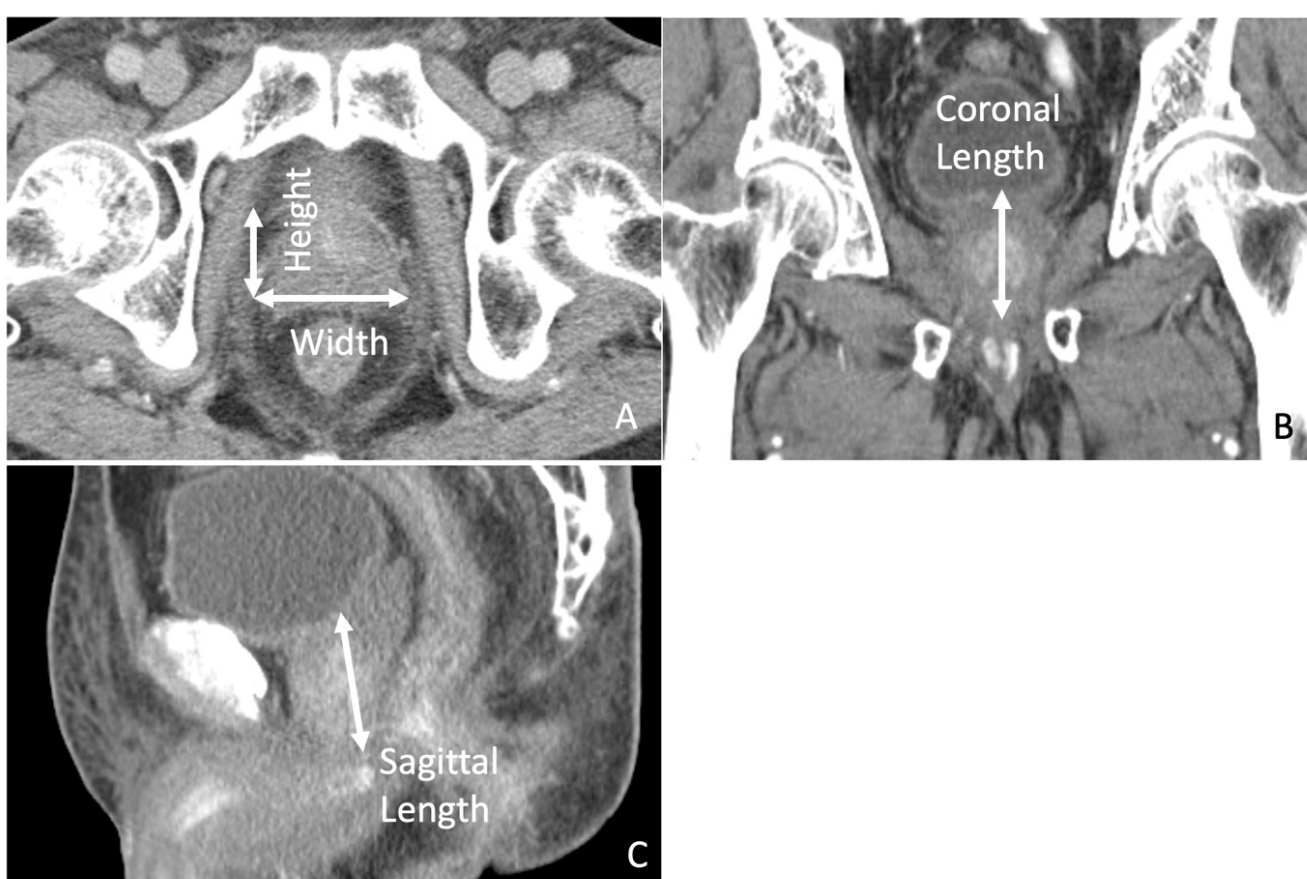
Measurement of prostate volume with ellipsoid method from CT scan. (A) Width (transverse diameter) and height (anteroposterior diameter) are measured by axial image (B) Coronal length (craniocaudal diameter) is measured by coronal image (C) Sagittal length is measured by sagittal image
